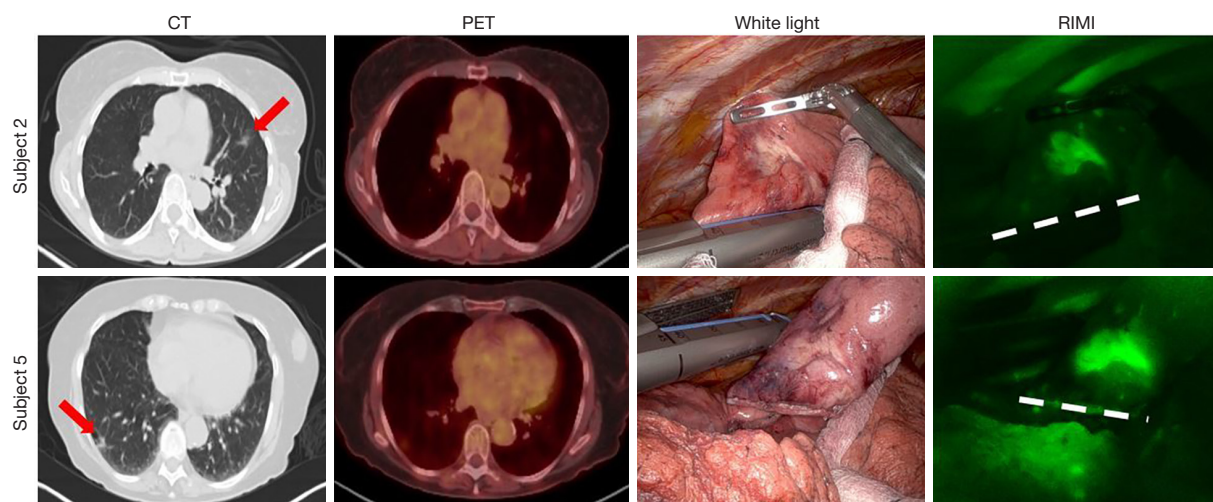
IMI during robotic-assisted thoracic surgery (RIMI) identifies pulmonary GGOs during robotic resection. This figure shows representative images from two patients enrolled in the study. Preoperative CT and PET scans are shown at left, with lesions marked by red arrows. The rightmost two columns show intraoperative white light and near-infrared images, with RIMI clearly identifying both lesions. The dashed line in the rightmost column indicates the stapled resection margin. CT, computed tomography; PET, positron emission tomography; GGOs, ground glass opacities; IMI, intraoperative molecular imaging.
